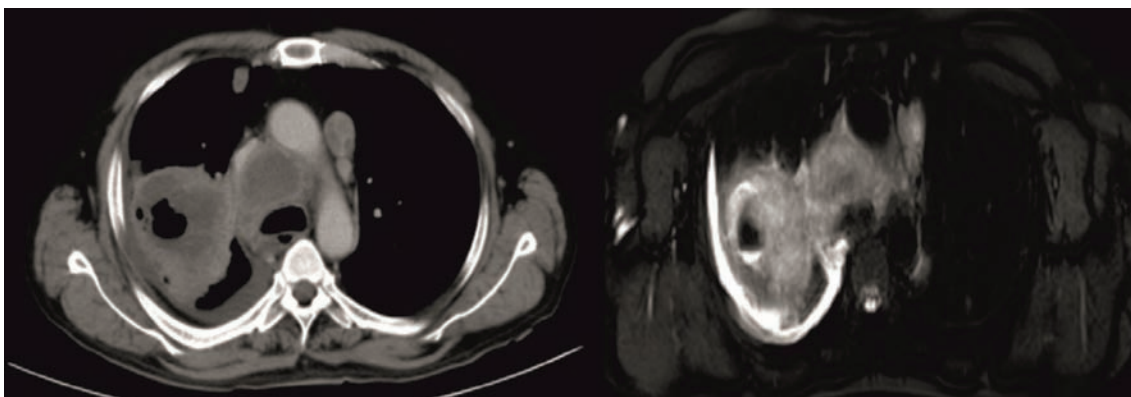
Axial CECT image (mediastinal window) (left) & axial fat-suppressed T2W MRI image (right) showing tumor with internal necrosis, necrotic mediastinal adenopathy and right sided pleural effusion
